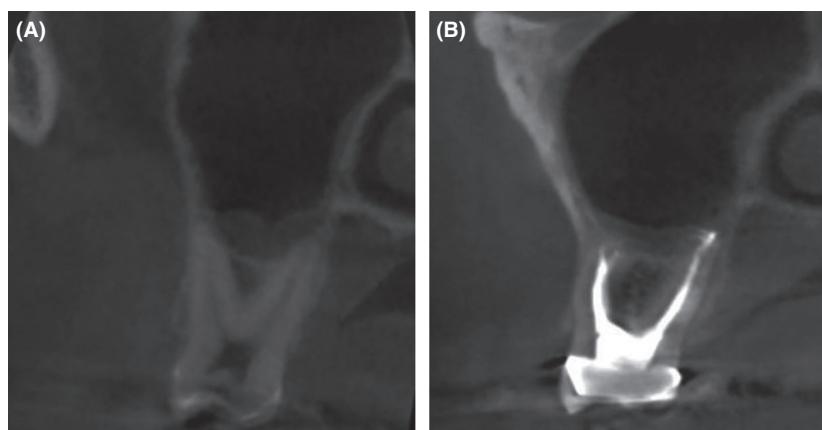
CBCT (A) before (B) and after 12-month GentleWave Procedure MB and DB roots.
